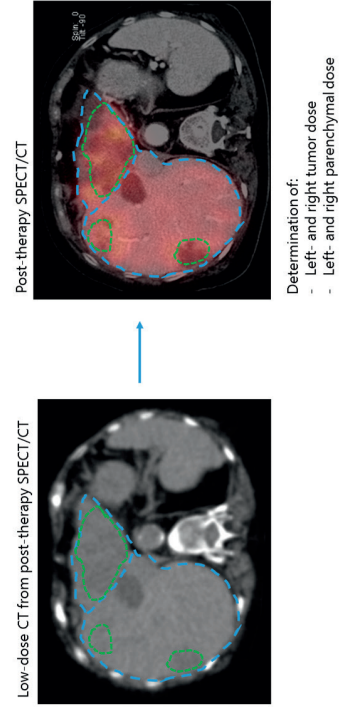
Stepwise process of absorbed-dose estimation after treatment. First, left- and right perfusion territories were manually delineated on the low-dose CT from the baseline [^{18}F]-FDG PET/CT, based on the cone-beam CTs (if available) or the baseline contrast-enhanced CTs. Afterwards, tumors were automatically defined on the baseline [^{18}F]-FDG PET/CT using a threshold-based approach. Then, the low-dose CTs of the baseline [^{18}F]-FDG PET/CT and the post-treatment ^{166}Ho -SPECT/CT were coregistered. Using a rigid transformation, the volumes of interest of the tumors and the healthy liver tissue (the left and right perfusion territories) were transferred to the ^{166}Ho -SPECT/CT and absorbed doses were obtained.
